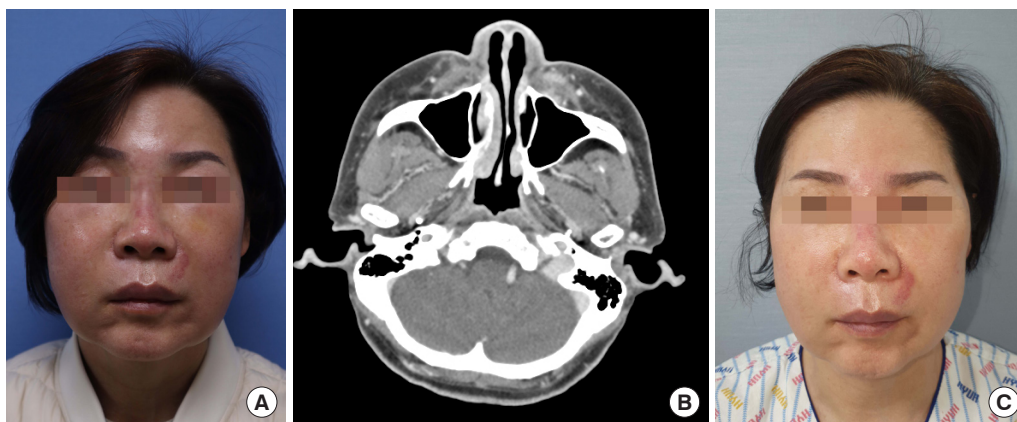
First delayed hypersensitivity reaction event. (A) Patient's photographs taken on the day she presented to the clinic. (B) Contrast-enhanced facial computed tomography scan shows ill-defined soft tissue densities, suggesting cellulitis. (C) Patient's photographs taken 3 days after hospitalization.
